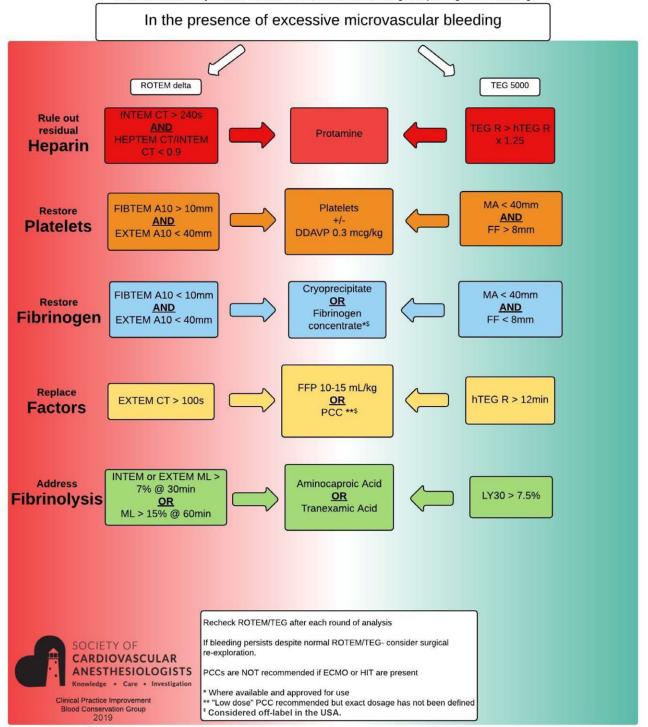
SCA ROTEM/TEG-based cardiac surgery intraoperative transfusion algorithm. ANH indicates acute normovolemic hemodilution; A10, amplitude at 10 minutes; CT, clotting time; DDAVP, 1-deamino-8-p-arginine vasopressin; ECMO, extra corporeal membrane oxygenation; EXTEM, extrinsic pathway thromboelastometry; FIBTEM, fibrinogen-based thromboelastometry; FF, functional fibrinogen; FFP, fresh-frozen plasma; Hb, hemoglobin; HEPTEM, heparinase thromboelastometry; HIT, heparin-induced thrombocytopenia; hTEG, heparinase thromboelastography; iCA++, ionized calcium; INTEM, intrinsic pathway thromboelastometry; LY30, clot lysis at 30 min; MA, maximum amplitude; ML, maximum lysis; PCC, prothrombin complex concentrate; R, reaction time; ROTEM, rotational thromboelastometry; TEG, thromboelastography.
